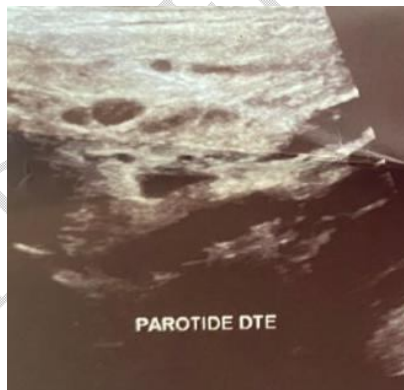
Ultrasound image after the resolution of the parotid abscess
